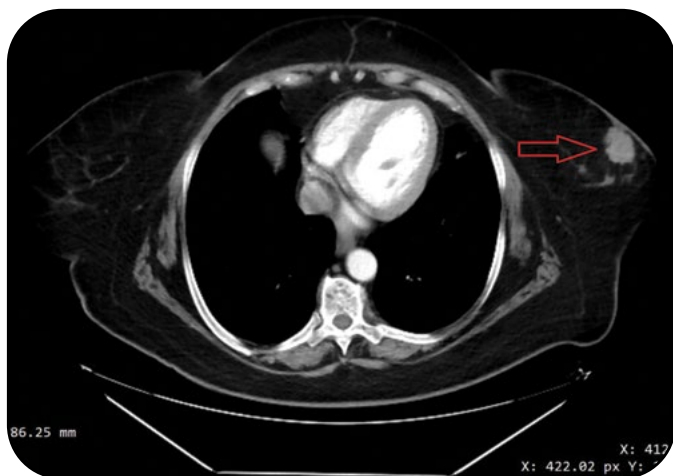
Chest computed tomography with contrast, arterial phase: pseudonodular tissue lesion in the infero-external quadrant of the left breast
